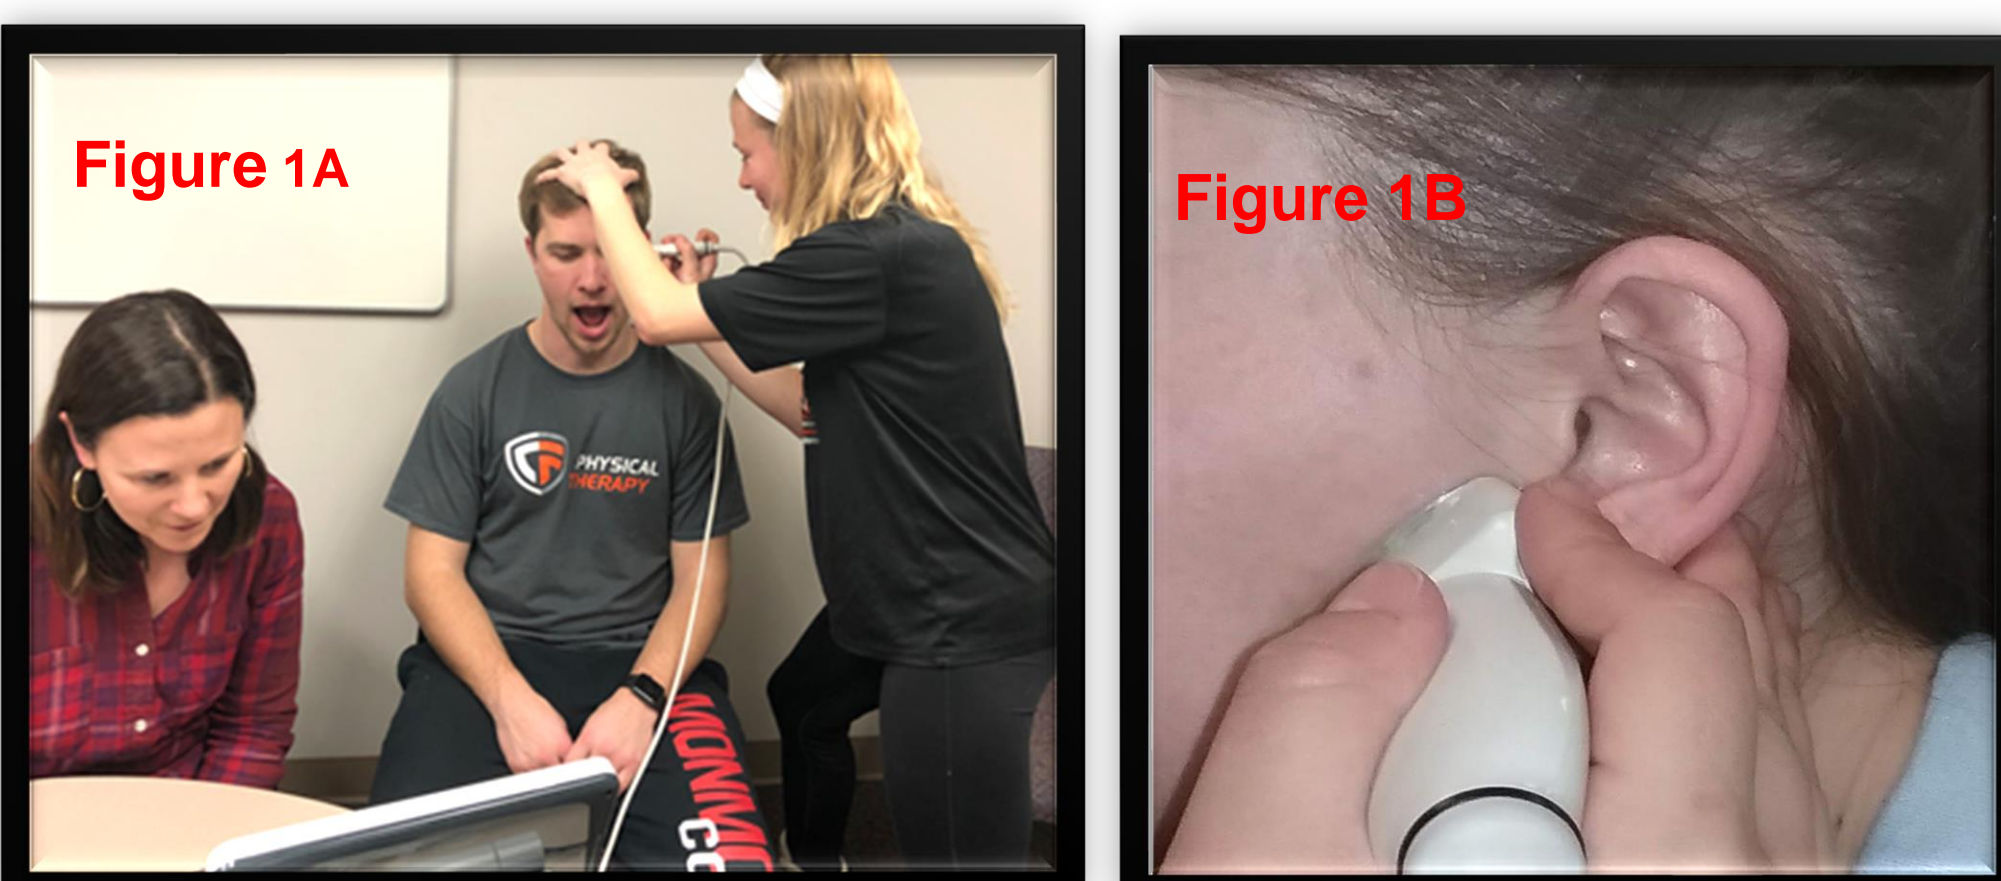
Positioning of the investigator, participant and ultrasound transducer for assessment & evaluation
